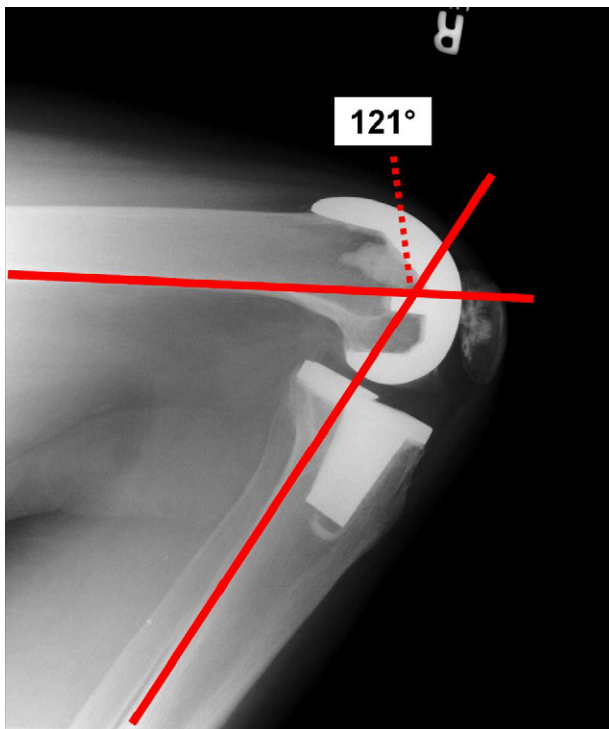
Radiograph showing measurement lines for knee flexion angle of 121°.
